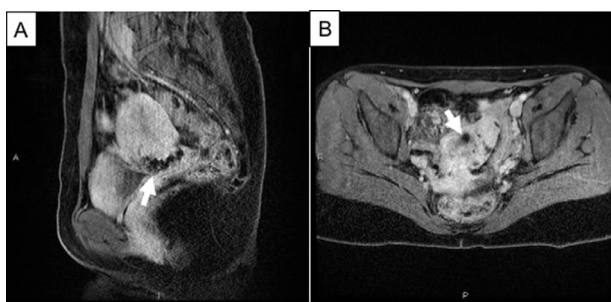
Same patient of Figs. 1, 2, 5, and 6. Postembolization MR acquired after 3 months. Contrast-enhanced T1-weighted MR in sagittal (A) and axial (B) planes showing enhancement of the uterus without opacification of the AVM represented by a dark serpiginous cast (white arrows).
